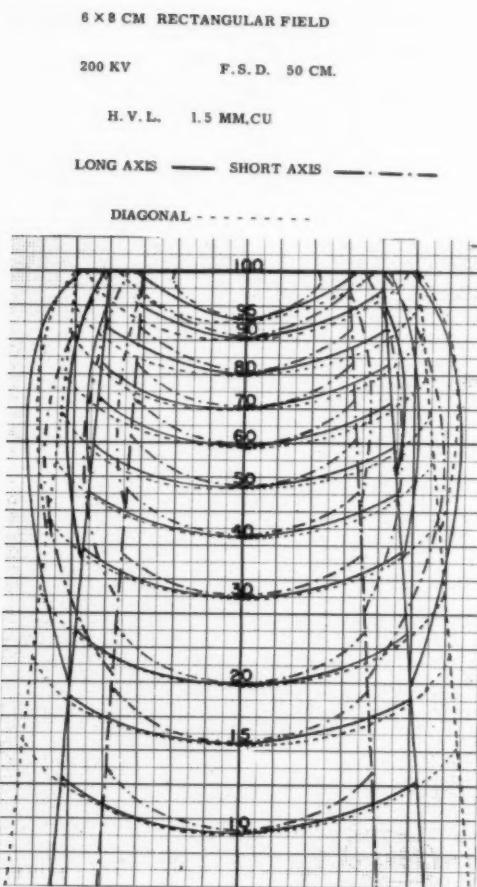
Triple isodose chart for 6 × 8-cm. rectangular field. X-rays generated at 200 kv; h.v.l. 1.5 mm. Cu; F.S.D. 50 cm. Isodose charts in planes of short axis, long axis, and diagonal.
